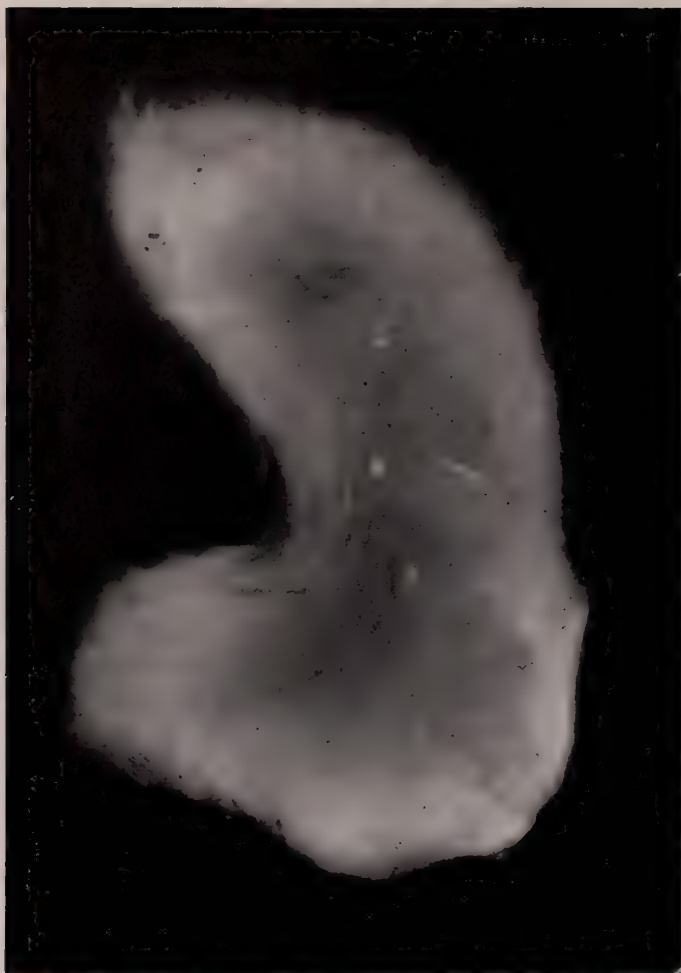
Roentgenogram of trichobezoar removed from the stomach shows metallic foreign bodies enmeshed within the hair ball.
